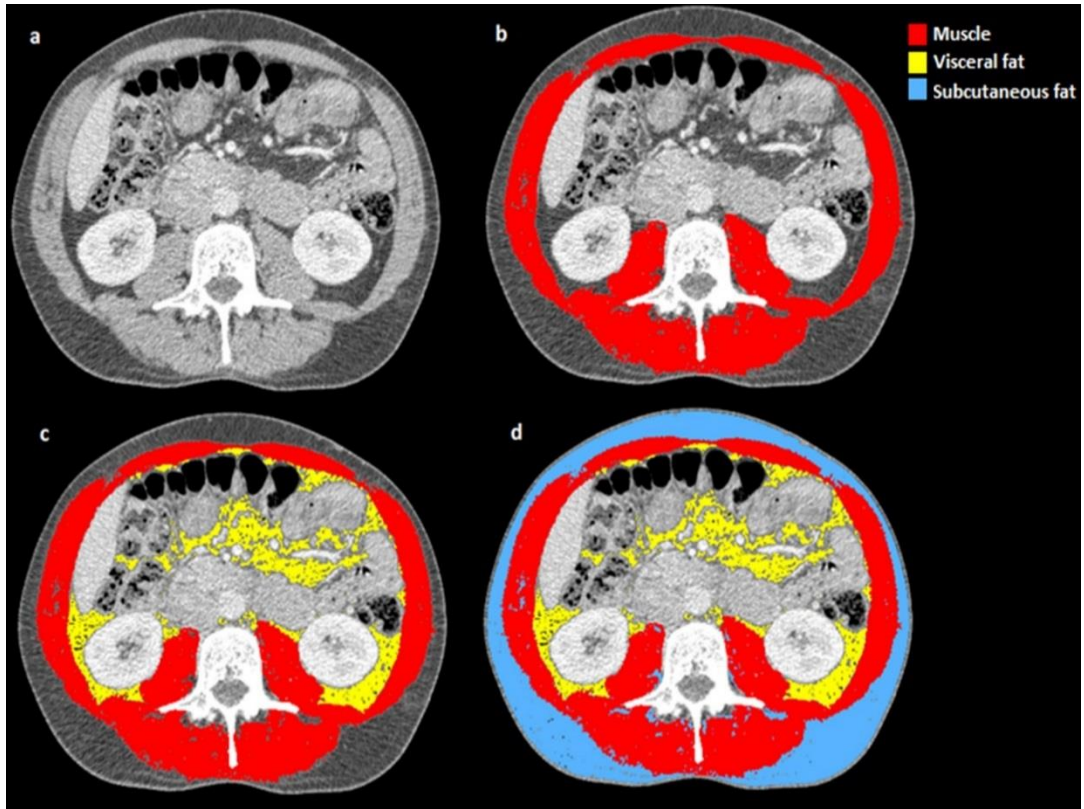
Cross sectional CT images at L3 showing demarcation of skeletal muscle and adipose tissue using Slice-o-matic software
